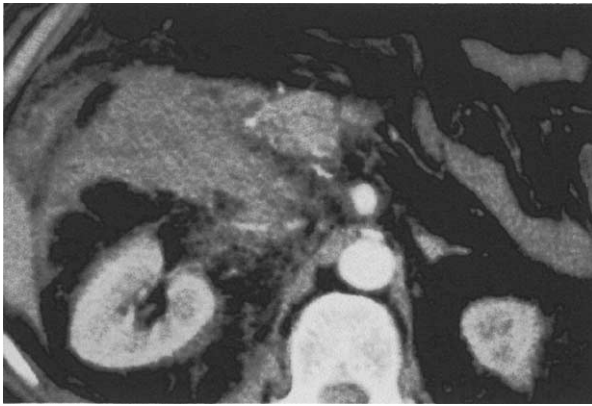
CT scan shows a large retroperitoneal hematoma and a median arcuate ligament division that compressed the origin of the celiac trunk.
